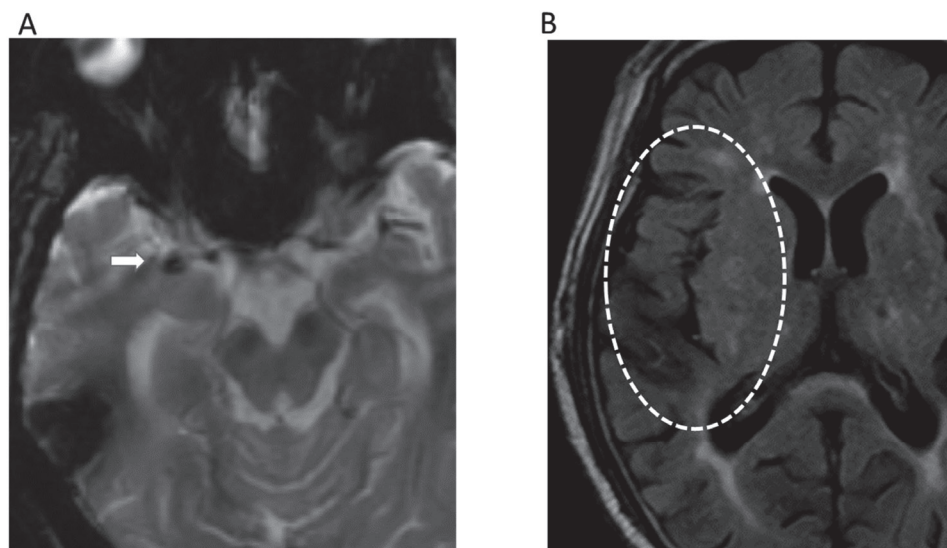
Representative MRI of middle cerebral artery occlusion due to cardioembolism (A : T2* ; B : FLAIR) Arrows in A indicate susceptibility vessel sign (SVS). Dotted circle in B indicates distal intraarterial signal.
